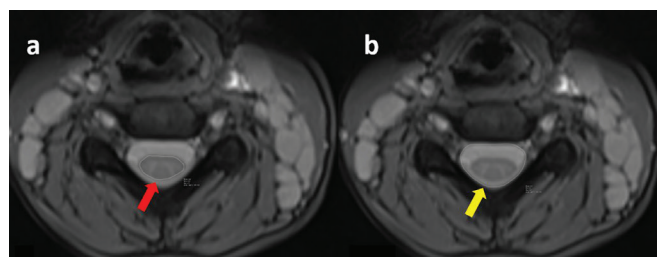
Axial T2-weighted cervical magnetic resonance imaging demonstrating cross-sectional area measurements at the C4 level. Panel (a) shows the measurement of the spinal cord cross-sectional area (indicated by the red arrow), while panel (b) displays the corresponding measurement of the spinal canal cross-sectional area (indicated by the yellow arrow). Both measurements were performed by manually tracing the outer contours of the spinal cord and spinal canal on the axial image acquired at the mid-vertebral body level of C4. Cross-sectional area measurements provide a more comprehensive assessment of the available space than linear anteroposterior diameter measurements alone, particularly when assessing canal morphology that deviates from a simple circular configuration.
